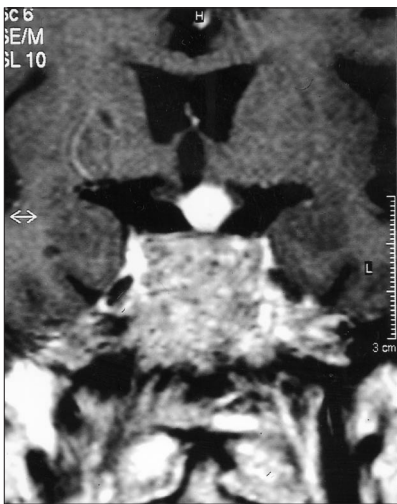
Magnetic resonance image of the pituitary showing destruction and infiltration of the pituitary and sphenoid with optic nerve deposit.
